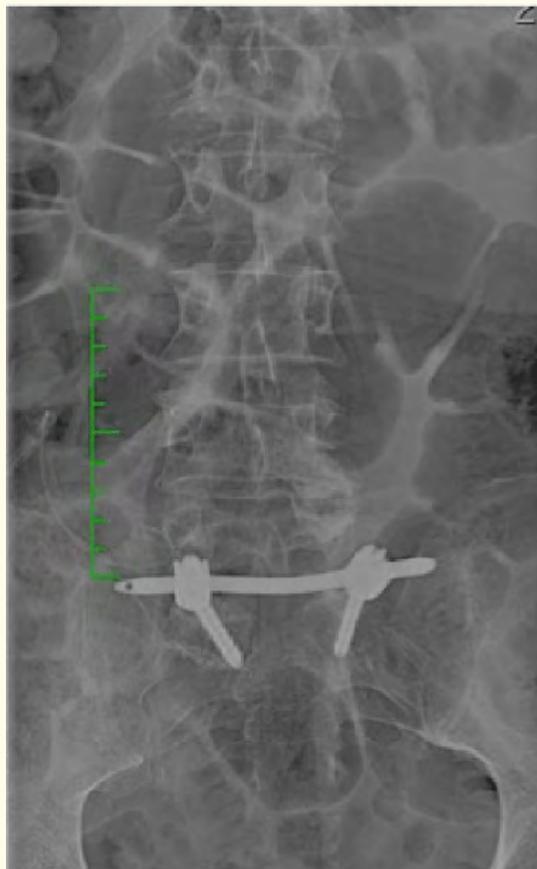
Post operative X-ray (AP projection).
